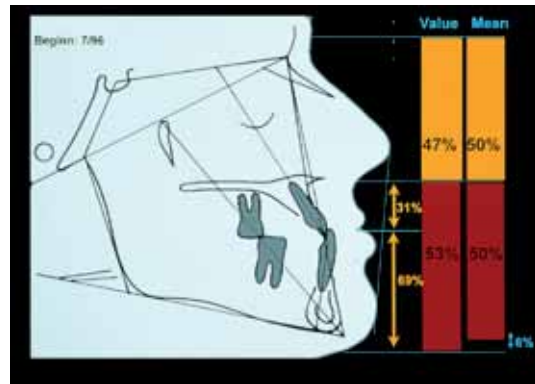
The cephalometric X-ray shows the disharmonious arrangement in the vertical axis. The lower face shows an approximately 60 percent enlargement in relation to the upper face.
